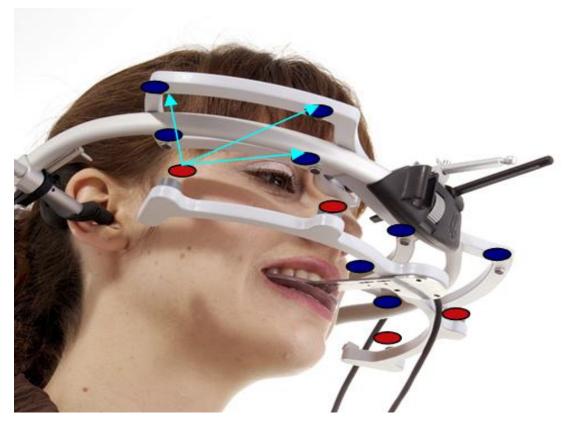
The Arcus Digma in its installed state. Also visible are the bite fork attached to the lower teeth and the associated transducer. The arrows show the possible path of the ultrasound signals from the transducer to the sensors.(30)
